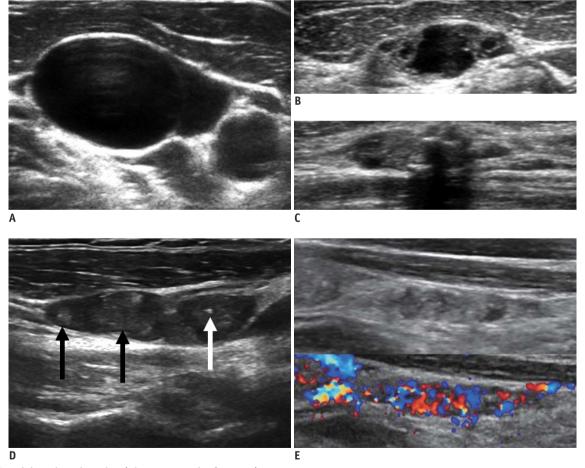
Suspicious lymph nodes (ultrasonography features).
